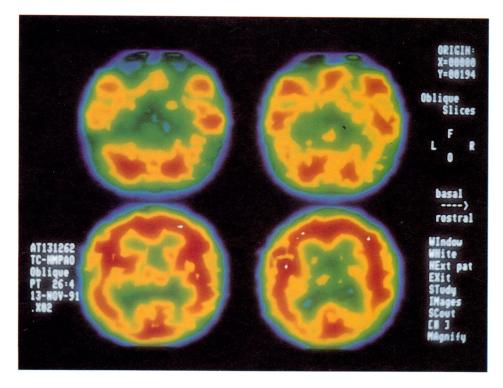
SPECT scanning shows diffuse uptake defects in this 30-year-old homosexual man; an elevated anticardiolipin antibody (ACA) titre was measured (42 GPL).
